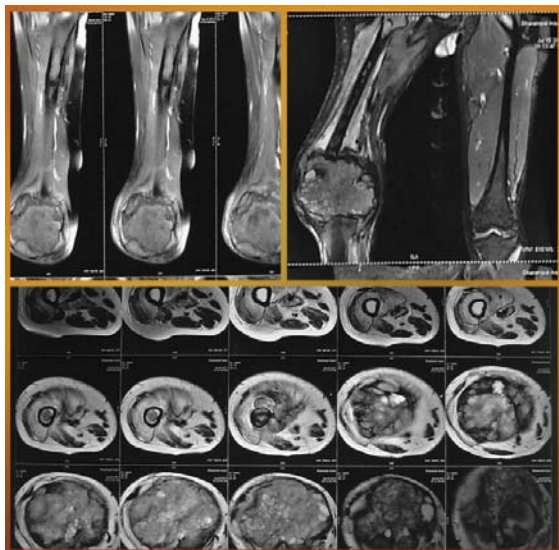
MRI images of distal femur GCT showing large tumor mass with central necrotic area
